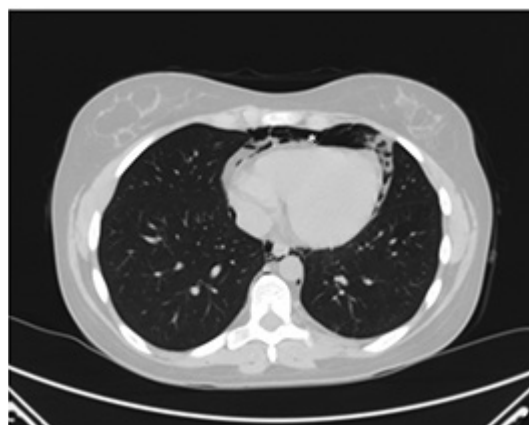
Abdominal computed tomography was remarkable for the presence of free air dissecting mediastinal space, consistent with pneumomediastinum (white asterisk).
